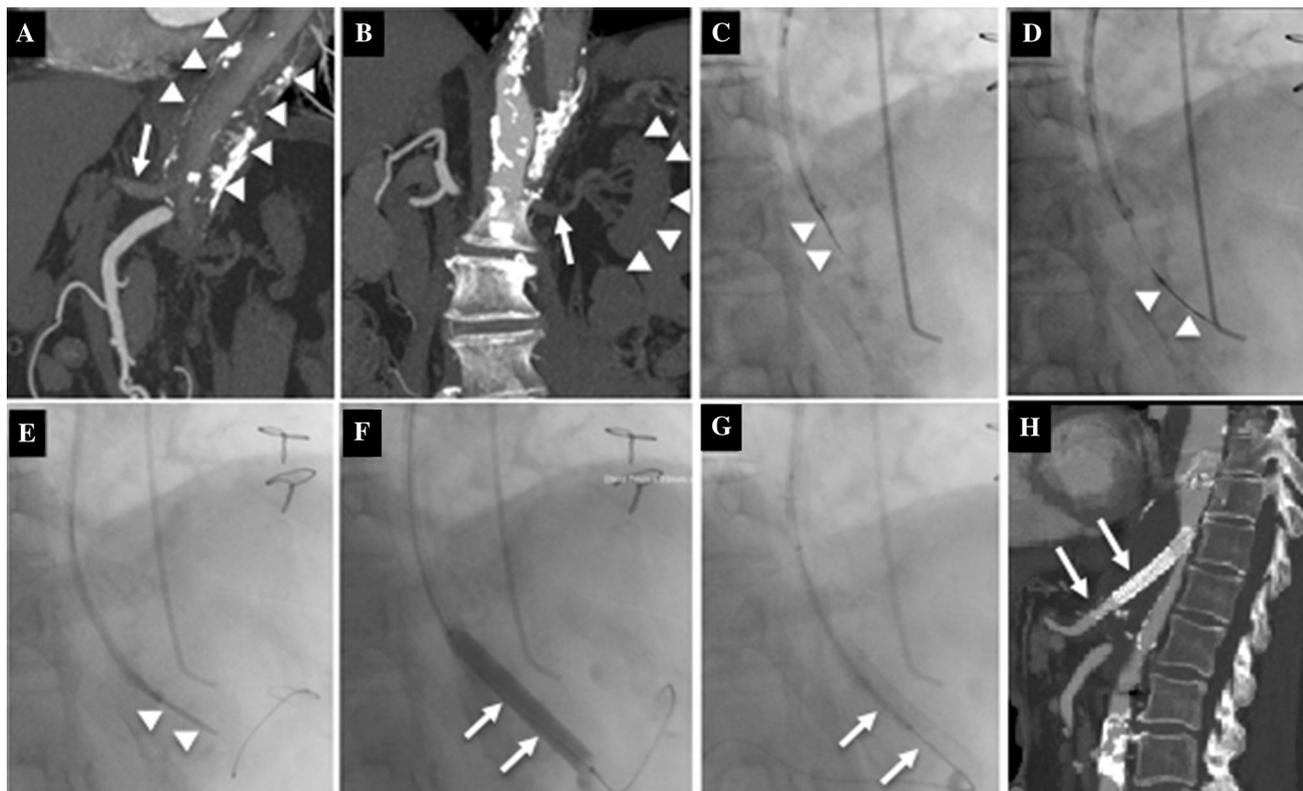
Images correspond to patient 1. A Sagittal maximum intensity projection (MIP) CTA demonstrating poor opacification of the coeliac trunk (arrow) and aortic false lumen (arrow heads) from which it arises and B non-opacification and non-perfusion of the left renal artery (arrow) and kidney (arrow heads) arising from the false lumen. Extensive intramural thrombus was present. C–G demonstrates stepwise advancement of the TruePath CTO device (arrow heads)
